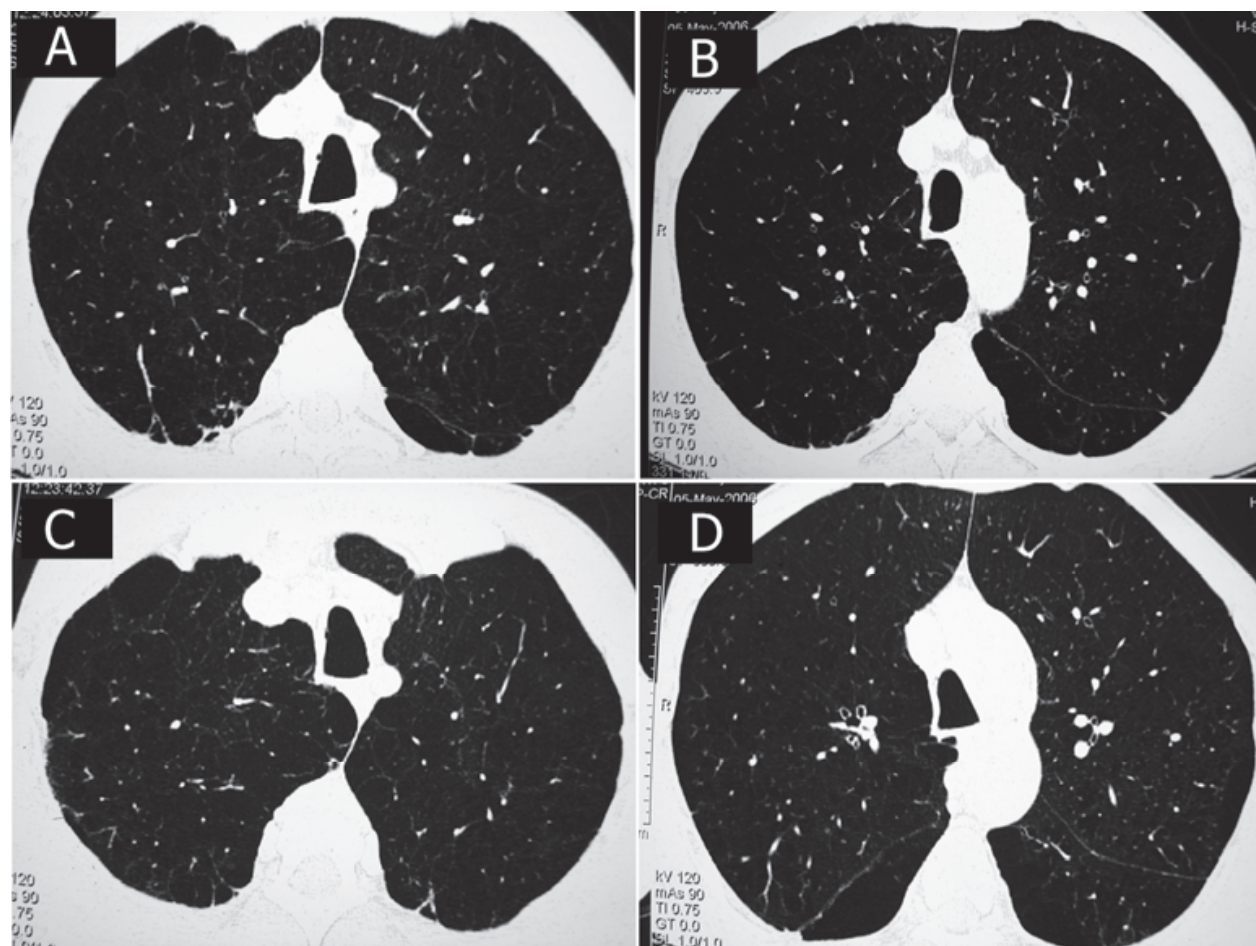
(A-D): Saber sheath trachea over CT scans in COPD patients
